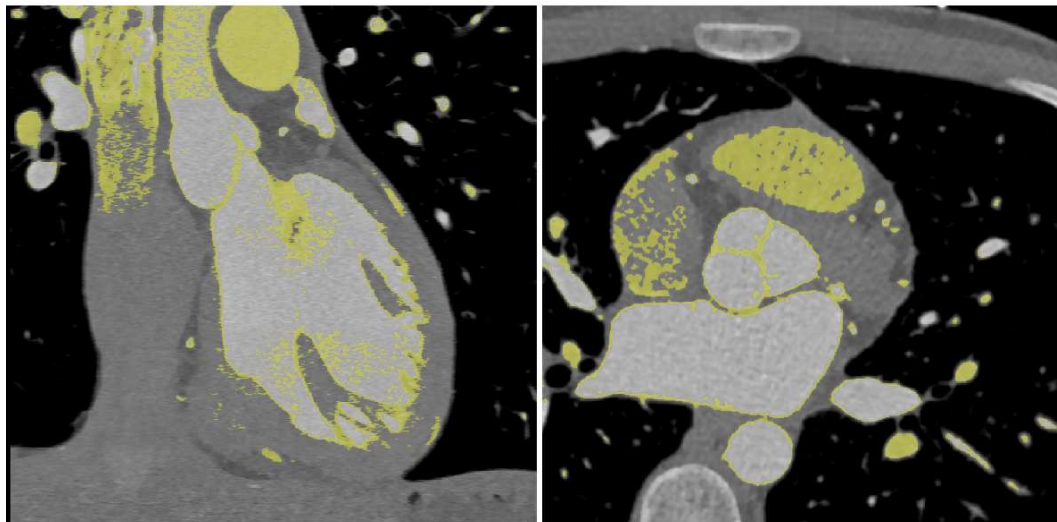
Sagittal and axial view of a CT scan during the segmentation process. Using a threshold, only the pixels within a certain range were selected, corresponding approximately to the density of endocardial tissue. The pixels corresponding to the endocardium and valves are therefore highlighted (in yellow).*
